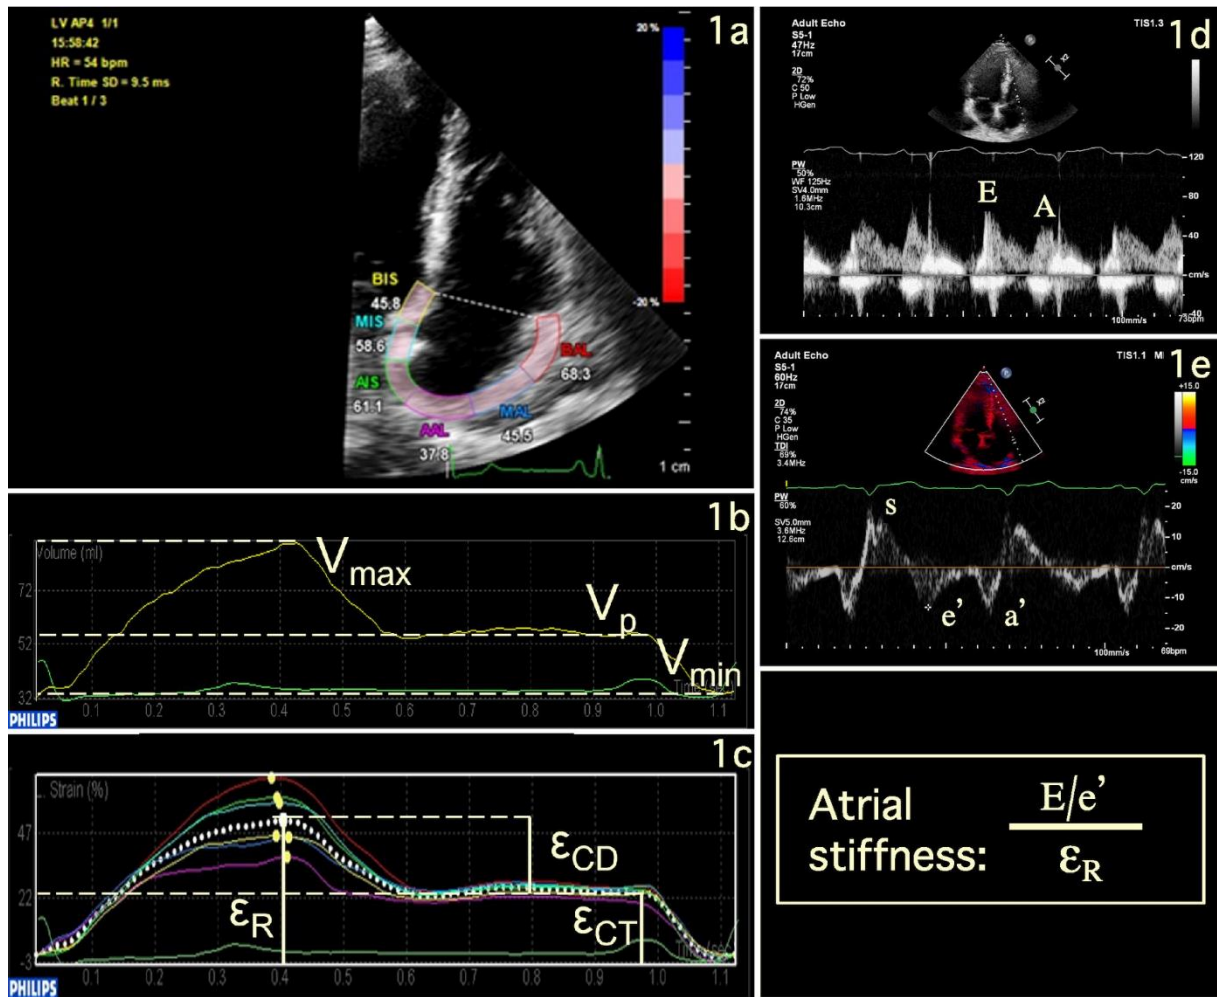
RV-focused apical 4-chamber view depicting the region of interest (1a) and the RA strain curve created by the speckle-tracking software (1c). Using the atrial borders created for speckle-tracking analysis, RA volume curves were generated by the same software (1b). Spectral Doppler curve of the transtricuspid flow (1d). Pulsed tissue Doppler curve measured on the lateral border of the tricuspid annulus (1e).
